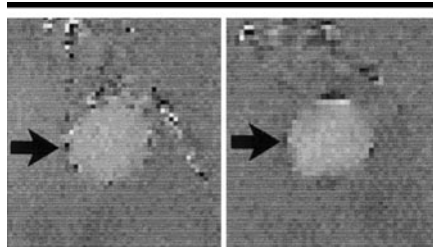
VEC MR imaging phase images (25/7; flip angle, 30°; section thickness, 5 mm) acquired during midsystole through Memotherm nitinol (left) and NuMed platinum (right) stents. Circular margin of the stents is well defined. The stents produced very small artifacts not exceeding a width of 2 pixels (arrow). Flow phenomena are visible over the entire stent lumina.
